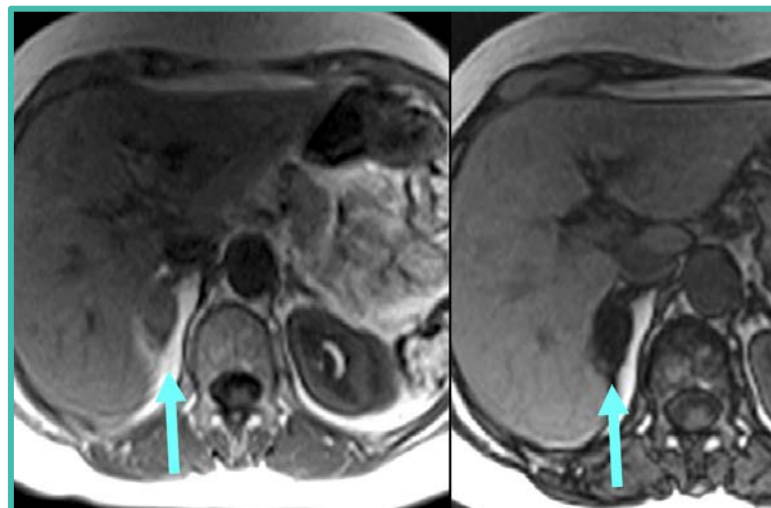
MRI chemical-shift sequence demonstrating homogenous signal drop in the right adrenal lesion on the opposed-phase compared to the in-phase (blue arrows)
